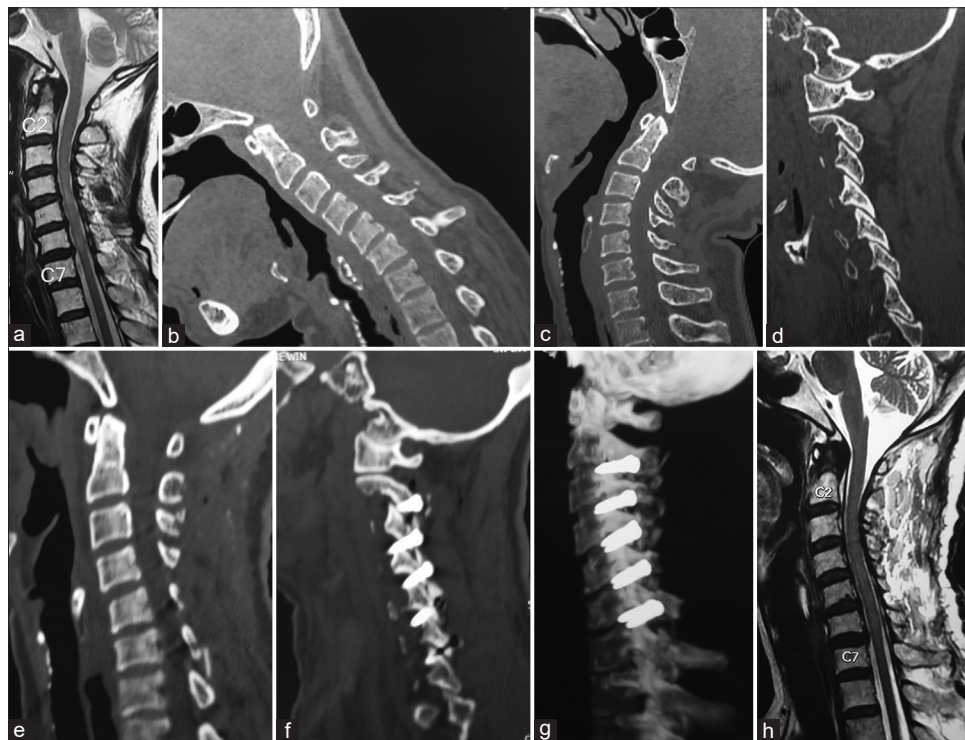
Images of a 57-year-old female patient [Table 1- Case 1]. (a) T2-weighted magnetic resonance imaging showing moderate cervical spinal degenerative changes in the form of bulging disc spaces and ligamentum flavum. Intra-axial cord signals are seen at C4-5 and C6-7 levels. (b) Computed tomography scan with the head in flexed position does not show any evidence of bone injury or instability. (c) Computed tomography scan with the head in the extended position. (d) Computed tomography scan cut passing through the facets showing no significant abnormality or instability. (e) Postoperative computed tomography scan showing the cervical spine alignment. No posterior decompression has been done. (f) Computed tomography scan cut through the facets showing transarticular fixation. (g) Computed tomography scan showing the fixation construct. (h) Delayed magnetic resonance imaging (after 3 months of surgery) showing regression of the osteophyte and resolution of intra-axial spinal cord changes
